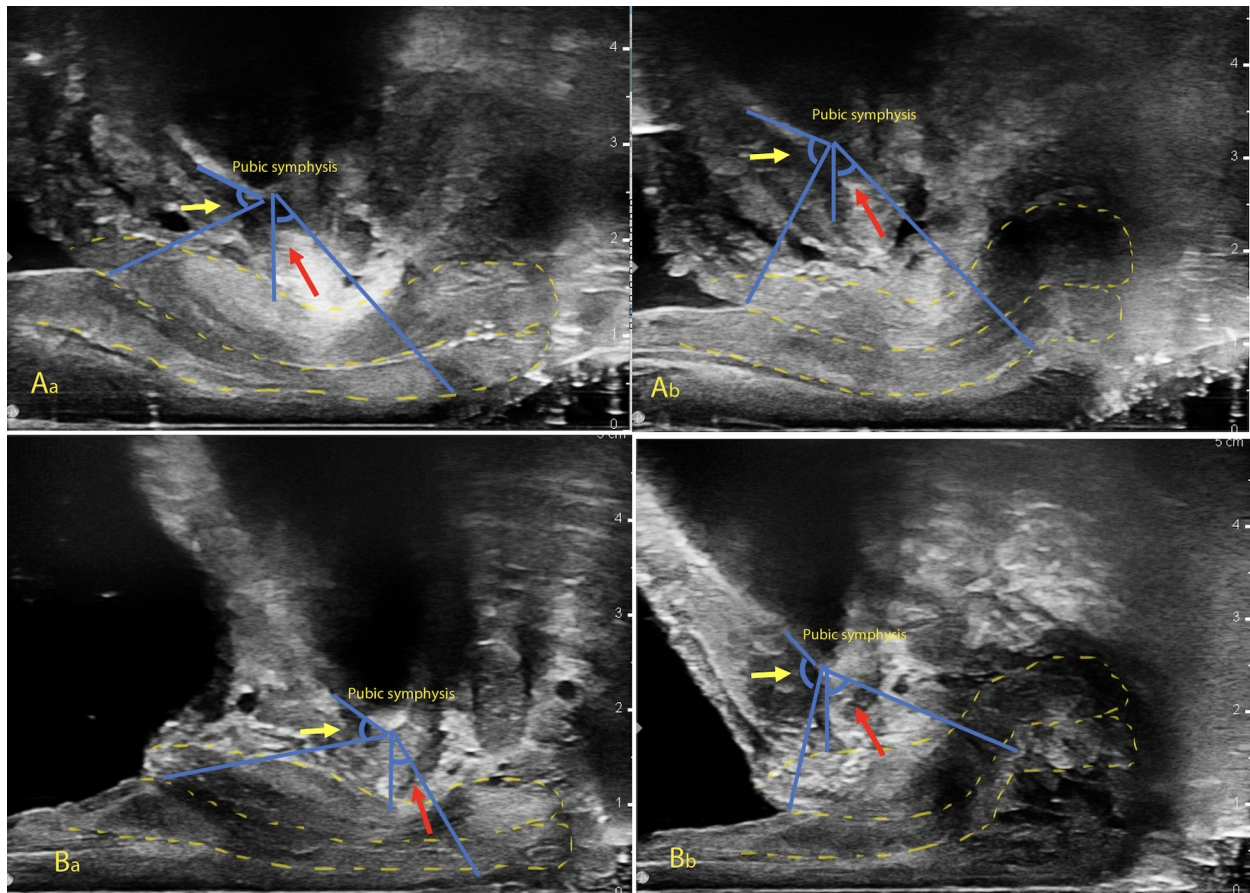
The anterior compartment visualized via dynamic endovaginal ultrasound in a urinary continent patient at (Aa) rest and (Ab) Valsalva and in a urinary incontinent patient at (Ba) rest and (Bb) Valsalva. The anterior and posterior urethral walls (outlined in yellow), retropubic bladder neck angles (yellow arrow), and urethral knee–pubic bone angles (red arrow) are indicated [164]. This figure was reprinted by permission from The International Urogynecological Association: Springer; International Urogynecology Journal; Megan R Routzong, Cecilia Chang, Roger P Goldberg, Steven D Abramowitch, and Ghazaleh Rostaminia. Urethral support in female urinary continence part 1: dynamic measurements of urethral shape and motion. *International Urogynecology Journal*, 2021; © 2021 The International Urogynecological Association.
